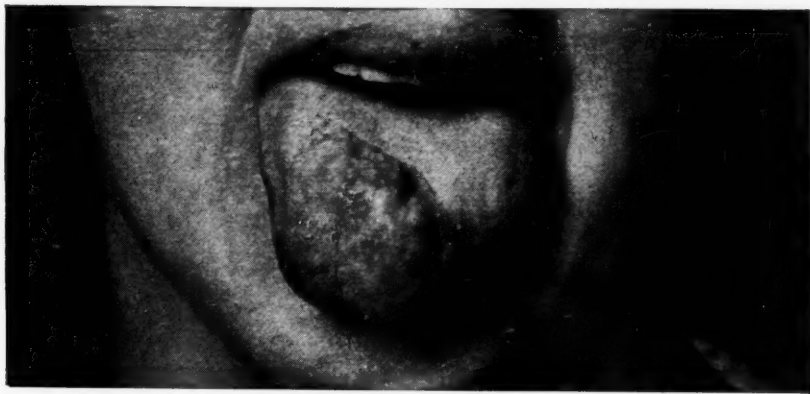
Pathol. No. 37052. Angioma of the tongue present at birth, slowly getting larger. One year x-ray treatment checked growth, but did not diminish size.
